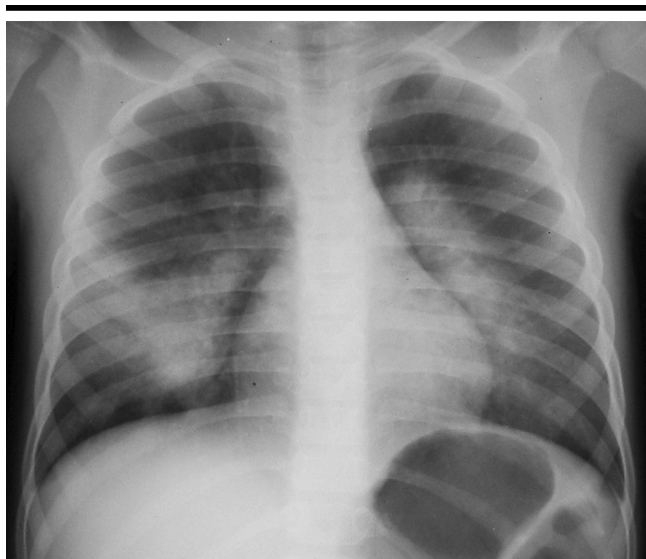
Frontal chest radiograph obtained in a 24-year-old woman several hours after blast injury shows bilateral opacities in a butterfly distribution, representing pulmonary contusion.
